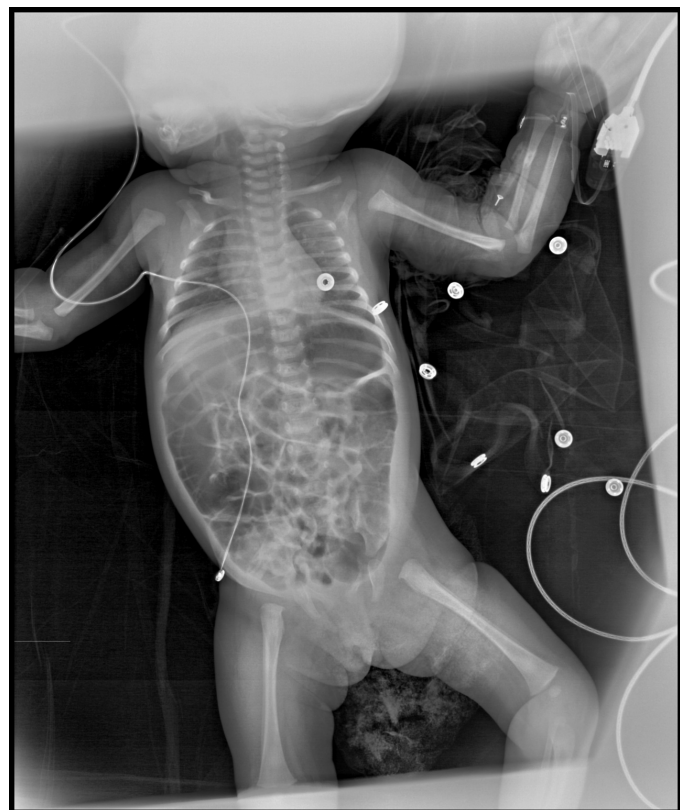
Chest X-ray findings of the patient: There is parallelization and flattening of the ribs, no active infiltration is observed
